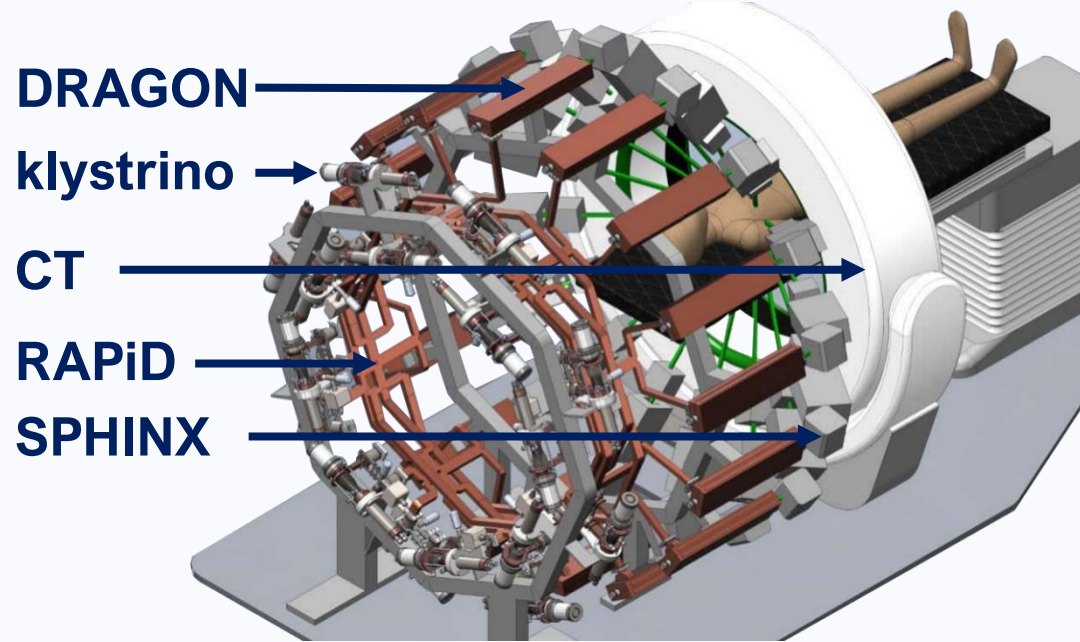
PHASER is a compact system for Bremsstrahlung-produced X-Rays; a network of 16 klystrinos is connected to 16 LINACs (DRAGONS), of cell-independent RF power distribution, followed by a system (SPHINX) of scanning magnets, Bremsstrahlung targets and collimators. The geometry shares the same isocentre with a CT scanner ring [8 - 9].
